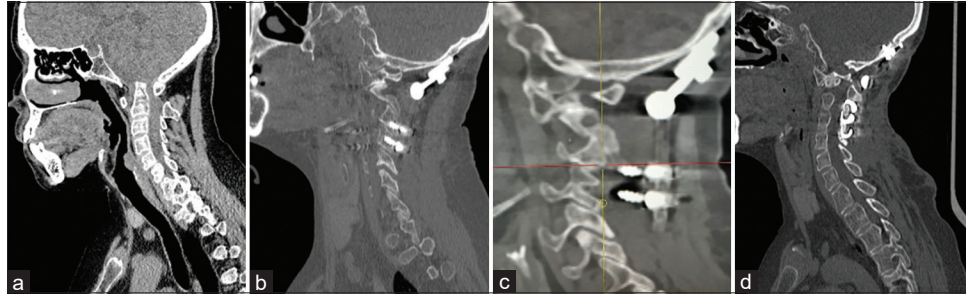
(a) Preoperative CT scan showing basilar invagination. (b) CT scan showing occipitocervical fusion with occipital plate screwed to the occipital bone and four screws inserted bilaterally in dysmorphic articular masses of C3 and C4. (c) C3 and C4 screws pull out. (d) CT scan performed after the second surgery: cervical articular screws were taken out and laminar clamps added to C3 and C4 laminae bilaterally.
